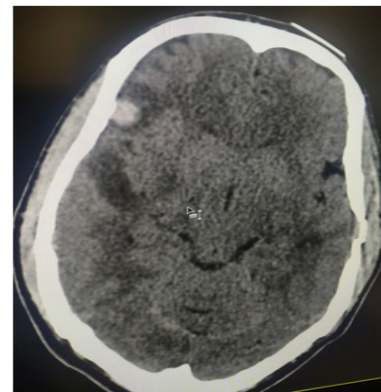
CT scan (Head) at Day 5: Increased peri-lesional oedema
